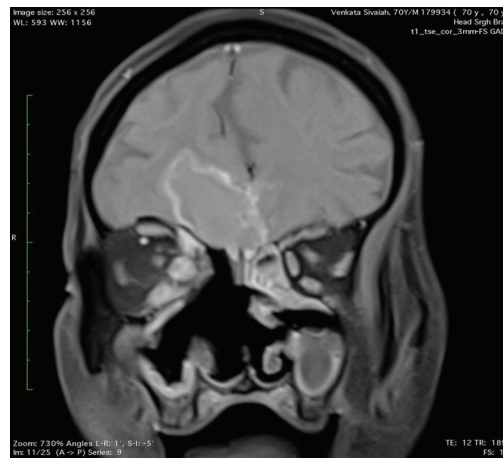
Coronal CE T1 weighted MRI image of case of mucormycosis showing enhancement in intraconal and extraconal compartments of right orbit medial to optic nerve with thickening of medial and inferior rectus muscles and peripherally enhancing lesion in right basifrontal lobe -S/o Orbital and intracranial extension.
